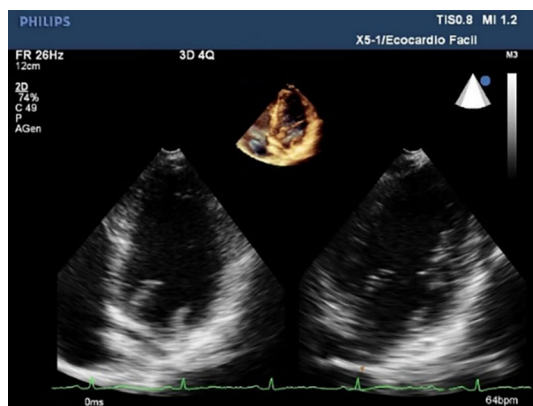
Ultrasound image of a patient heart
